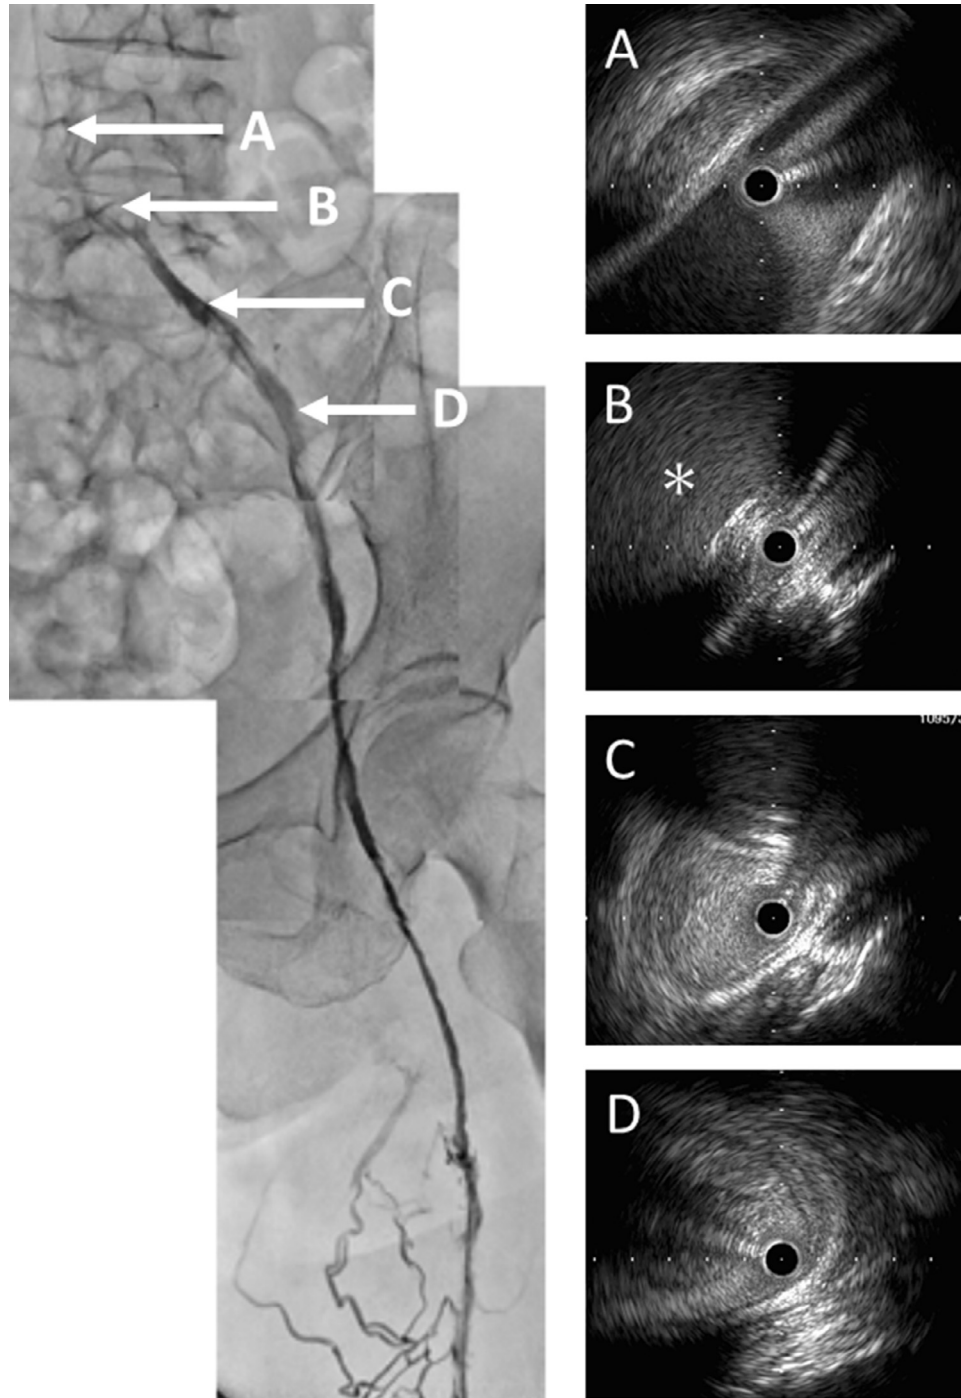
Venography and IVUS findings in the second session of endovascular treatment. IVUS images were indicated the right common iliac artery compressing the left common iliac vein. IVUS, intravascular ultrasonography.
